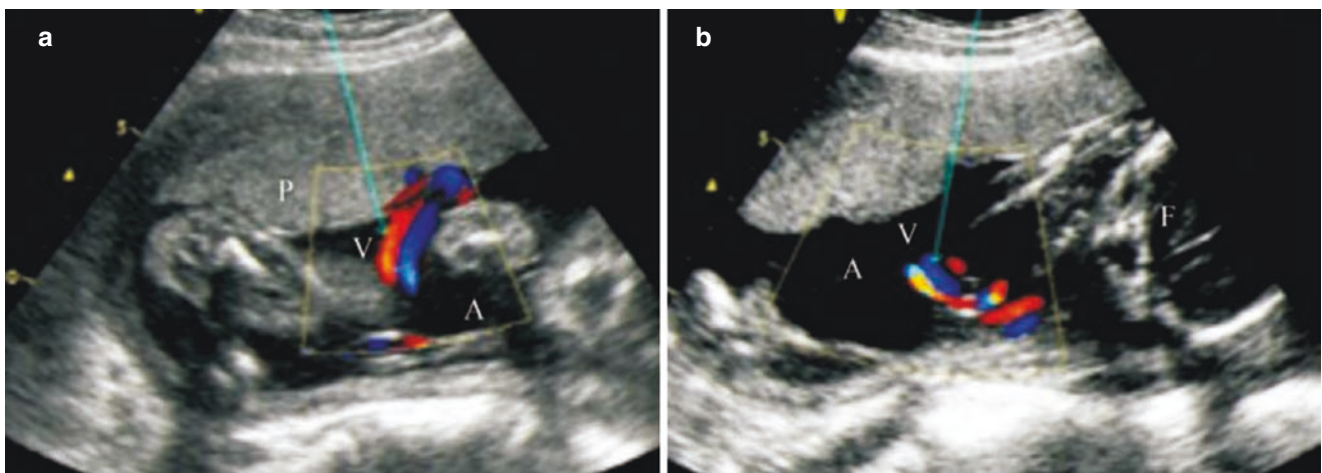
Ultrasound-guided umbilical cord puncture. (a) Puncture is performed on the side of the placenta. (b) Puncture is shown on the free segment of the umbilical cord
